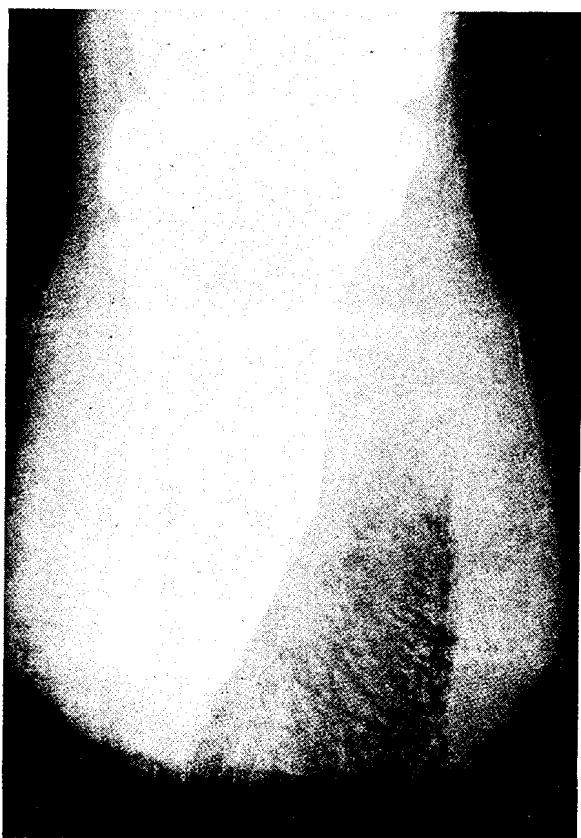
Case 92. Area of gas developed despite early x-ray therapy, which was given simultaneously with sulfanilamide administration.
